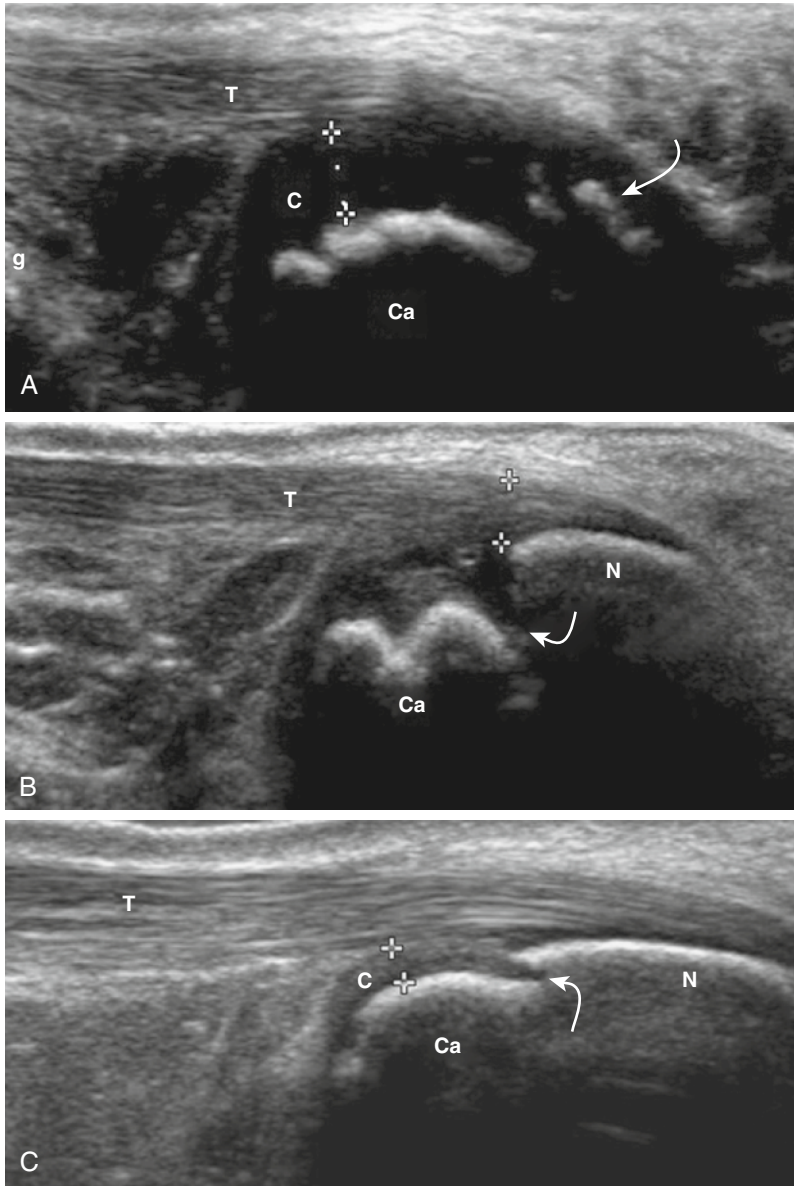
1 A, Ultrasound shows a normal calcaneal enthesis in 4-year-old girl. The secondary ossification center can be seen (arrow). The interface of bone and cartilage has the appearance of a wave. B, In a 10-year-old boy, the secondary ossification center is not fused with the calcaneus. C, In an 11-year, 3-month-old girl, fusion between the ossification center (C) and the calcaneus has not yet occurred, and there is a gap in between the structures (arrow). Ca, calcaneus; N, ossification center; T, tendon.
